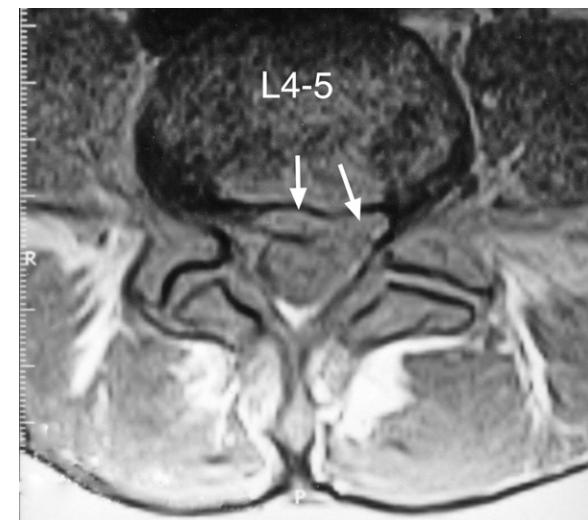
MRI axial T1-weighted image showing the L4-5 prominent central to left sided disc protrusion (arrows).
